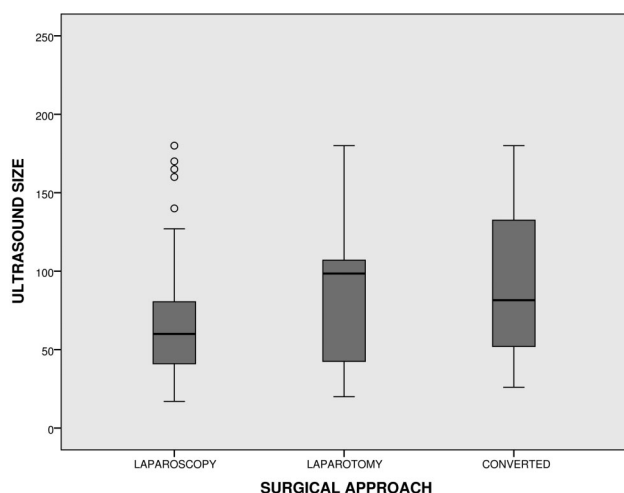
Ultrasound size and surgical approach.
